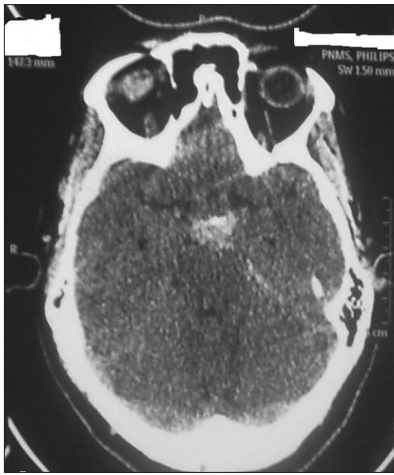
Computed tomography scan plane showing blood in mesencephalic cisterns
